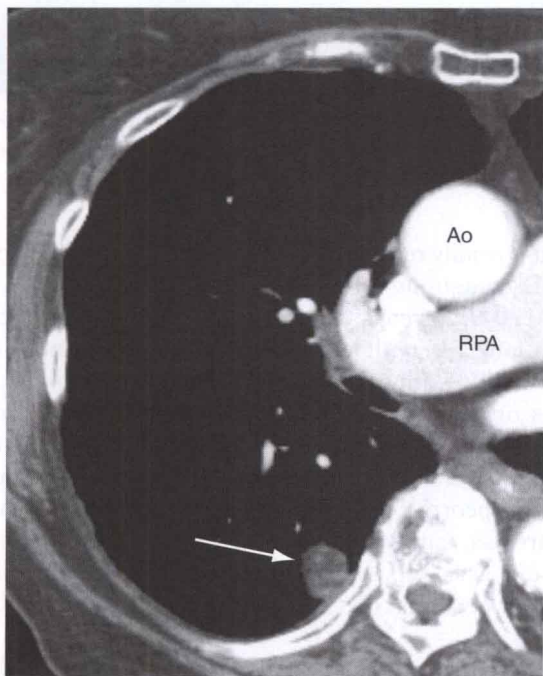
The patient was an 80-year-old woman in whom imaging was performed as follow-up for treated esophageal cancer. Contrast-enhanced chest CT scan shows a 2-cm nodule in the right lower lobe (arrow). The nodule is of mixed attenuation and contains fat that is similar in CT appearance to the subcutaneous fat, with attenuation of -80 HU, consistent with a hamartoma. The nodule showed no significant growth at 4-year follow-up evaluation by chest CT (not shown). Ao, aorta; RPA, right pulmonary artery.
